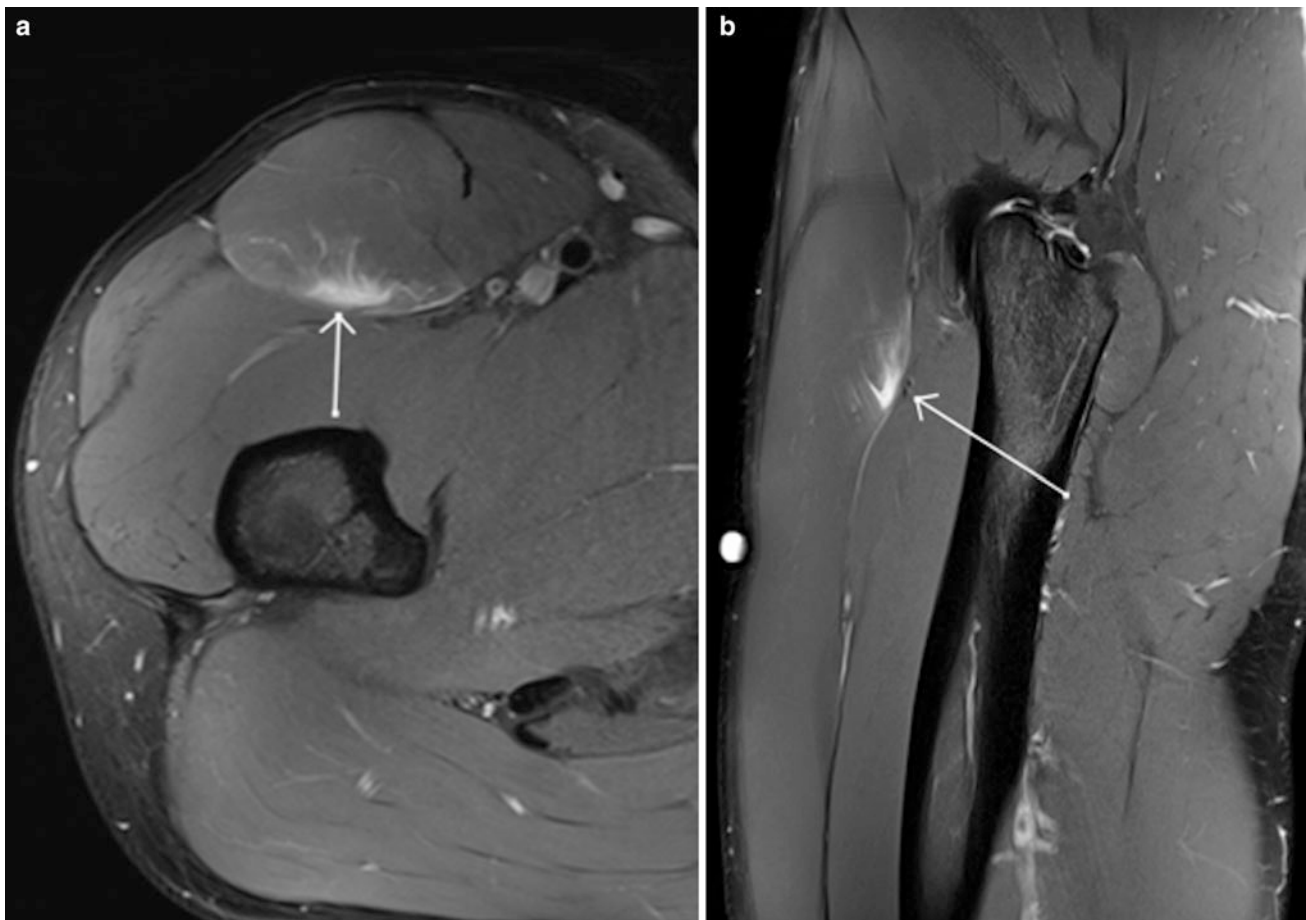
Axial (a) and sagittal (b) proton density weighted MR images with fat saturation show a grade 1 epimyseal muscle strain injury of rectus femoris, manifest as eccentric-peripheral muscle oedema, without muscle fibre discontinuity (arrows)
